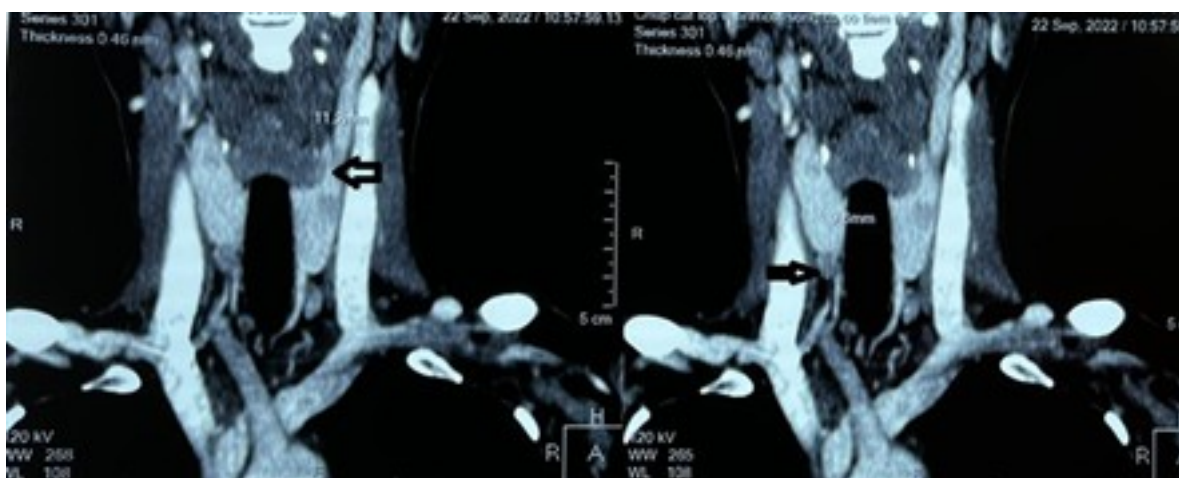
Computed tomography of left (1st) and right (2nd) parathyroid gland
